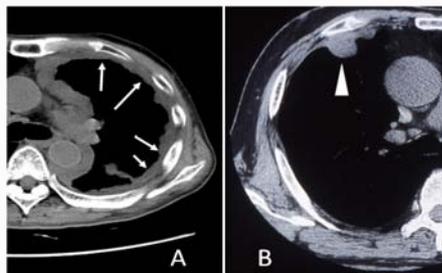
CT, mediastinum window.
